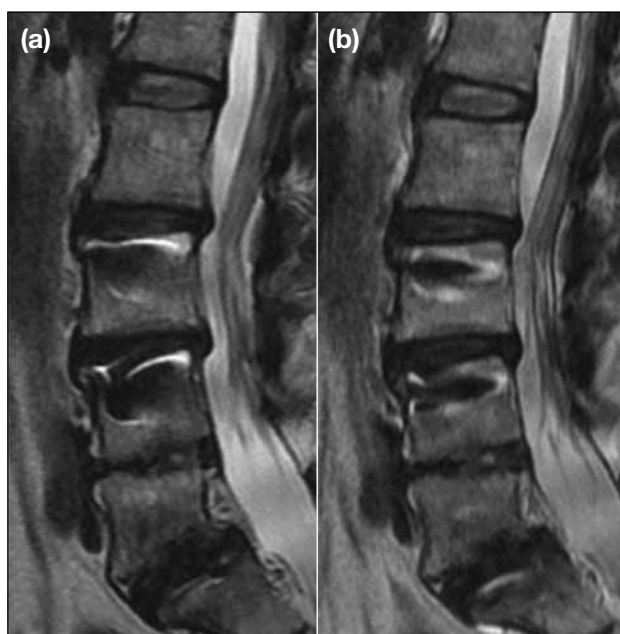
T2-weighted sagittal images of the spine showing (a) metallic susceptibility artefacts from screws, and (b) artefacts decreased by metal artefact-reduction techniques using a spin-echo pulse sequence with short echo spacing, maximising receiver bandwidth with acceptable level of signal-to-noise ratio, and reducing slice thickness with parallel imaging acceleration.
